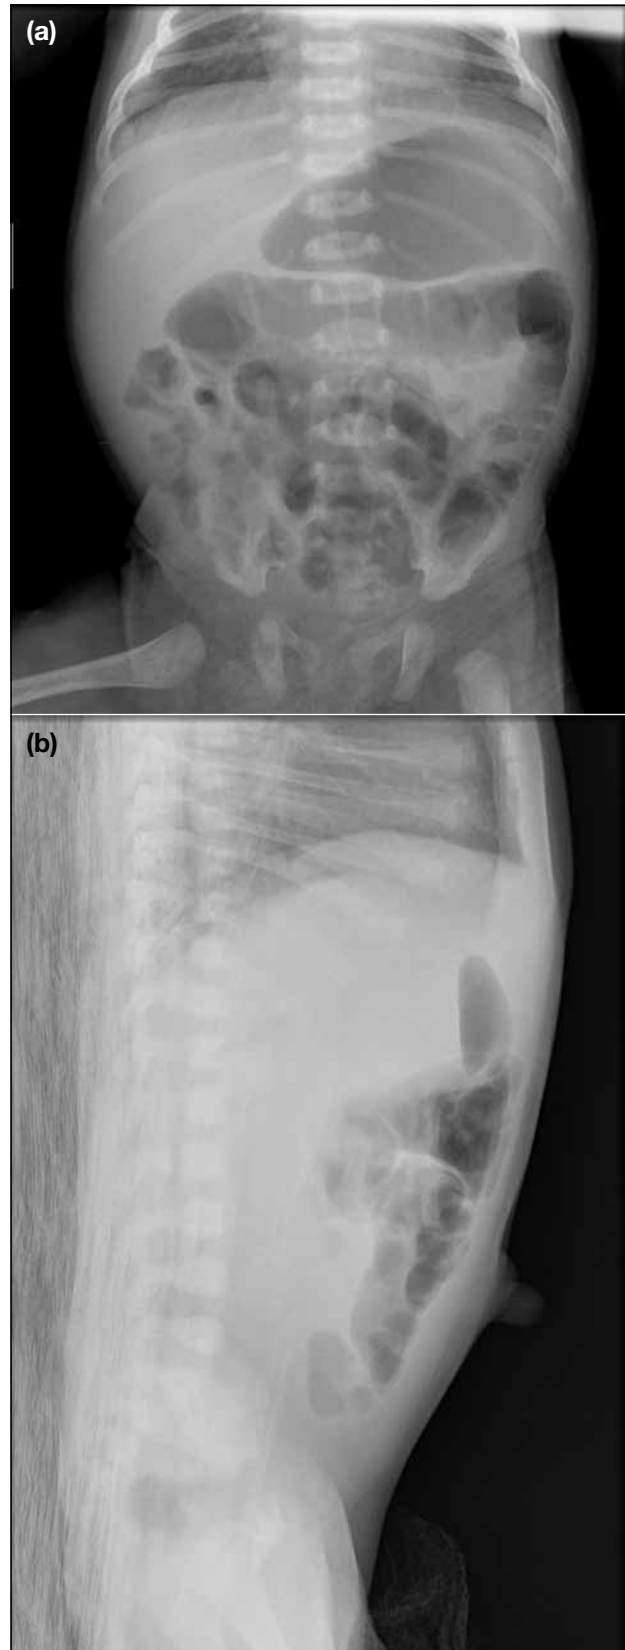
Abdominal radiographs showing (a) normal bowel pattern, with no abnormal calcification or displacement of bowel loops, and (b) the soft tissue umbilical nodule on lateral radiograph.
